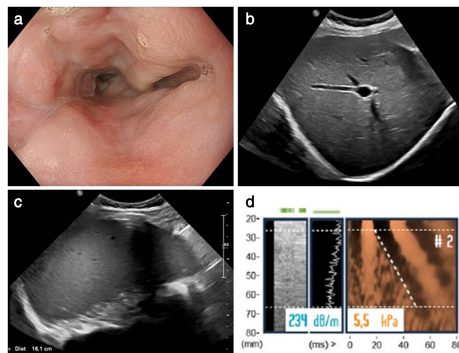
Upper gastrointestinal endoscopy showing Grade 2 esophageal varices (a); abdominal ultrasound revealing normal liver surface (b) and a splenomegaly (c) and vibration-controlled transient elastography results showing normal liver elasticity compatible with the absence of fibrosis (d).
